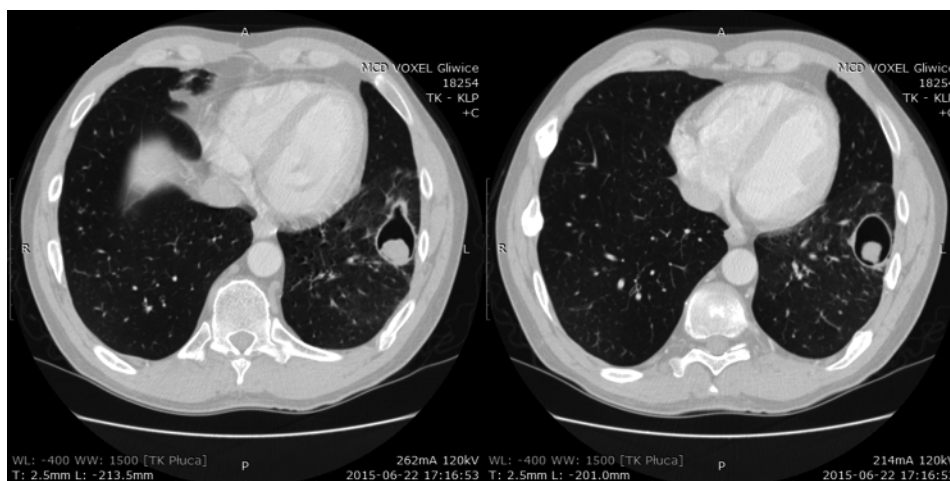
Chest computed tomography — 31 × 39 mm cavity with 17 × 25 mm soft tissue structure in the lower, left lobe
